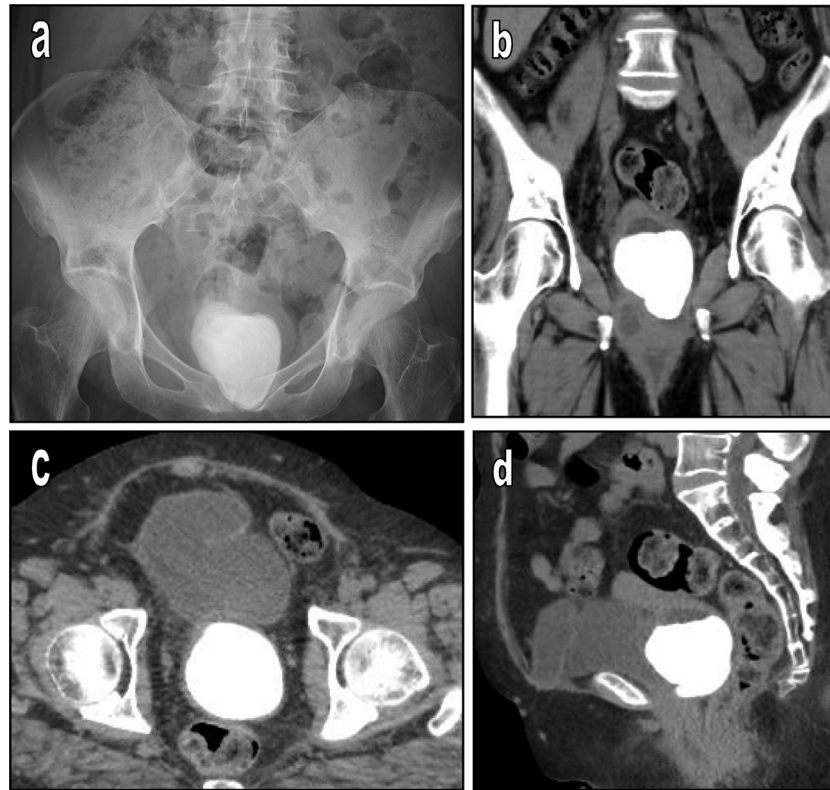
Complementary digital radiographic and CT examinations. (a) Digital radiographic examination in antero-posterior supine view and (b–d) coronal, axial and sagittal 2D multiplanar non contrast CT images. The vaginal stone appears as large opaque stone projected over the bladder in the plain film. Its location within the vagina is clearly seen in reformatted CT images. It indents the posterior wall of the urinary bladder with obvious line of cleavage with the rectum posteriorly and clear deep pelvic fat planes.
